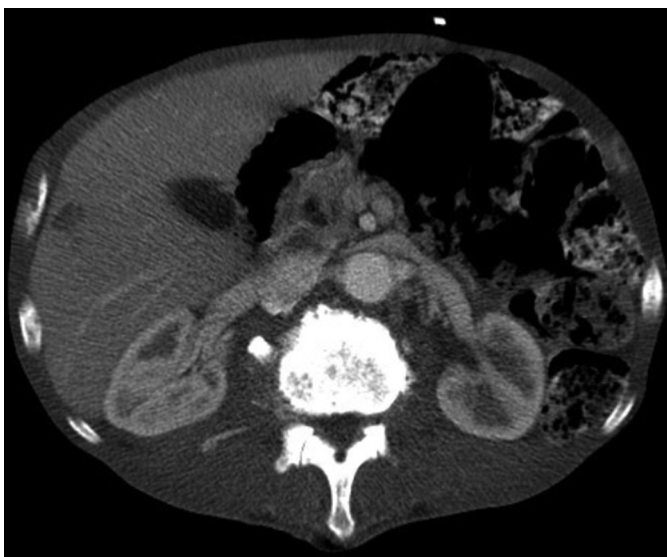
Abdominal computed tomography scan showing a 1.8×1.1 cm low-density lesion in the right lobe of the liver, indicating nearly complete resolution of the pyogenic liver abscess.
